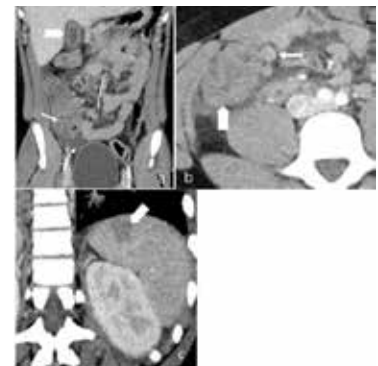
Contrast enhanced CT abdomen and pelvis of a 15-year-old male who presented with sepsis. (a) Coronal image of the abdomen demonstrates gallbladder wall oedema (wide arrow). There is extensive thickening of the cecal wall thickening (thin arrow) and free-fluid within the pelvis (dotted arrow). (b) Axial slice through the lower abdomen showing the cecal wall thickening (wide arrow) with multiple adjacent mesenteric nodes (thin arrow) and surrounding fat-stranding. (c) Coronal image through the left upper quadrant shows a focal subcapsular, hypoattenuating region within the spleen in keeping with a splenic infarct (arrow).
